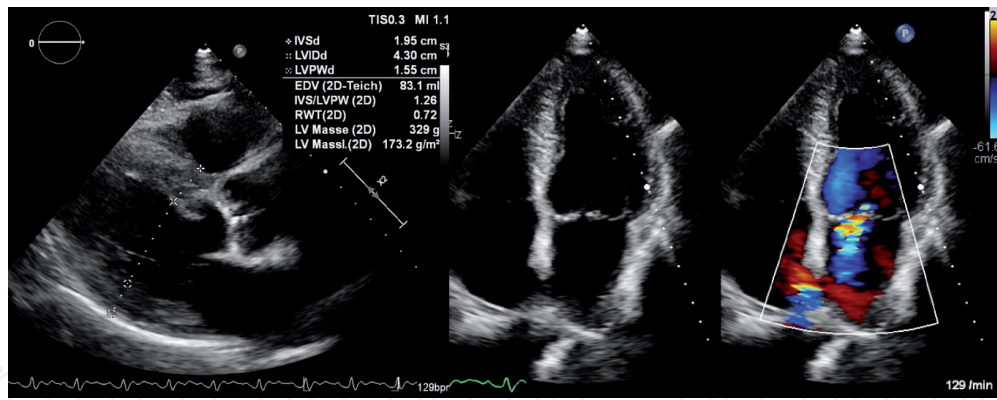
Echocardiographic imaging showing a parasternal long axis view of a left ventricular hypertrophy and an apical 4-chamber view demonstrating mitral regurgitation.
